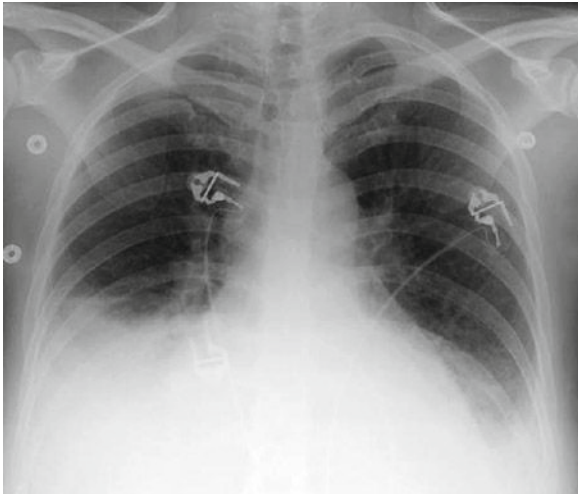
Chest X-ray at ICU admission showing bilateral interstitial pneumonia and lower right lobar alveolar syndrome with atelectasis
